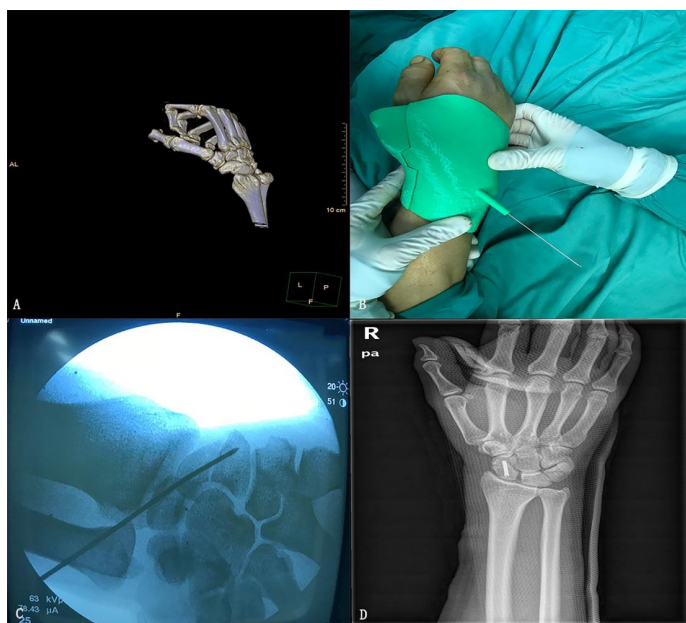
The whole procedures of another operation. A. CT scan of another patient of scaphoid fracture. B. Drilling of K-wire through guiding hole of template. C. Fluoroscopy of the K-wire in the scaphoid. D. Fluoroscopy of the site of hollow screw after operation.
